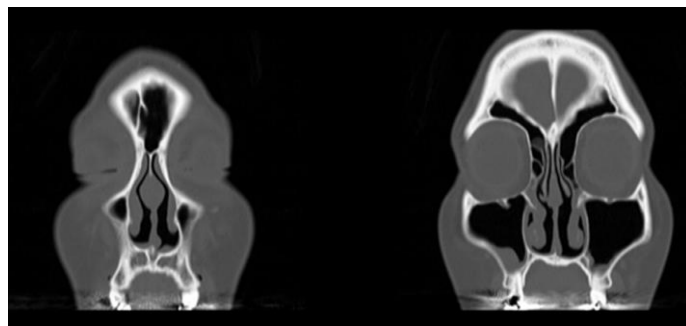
Computed tomography (coronal view), showing reduction of inferior turbinate 1-month post-operative.
